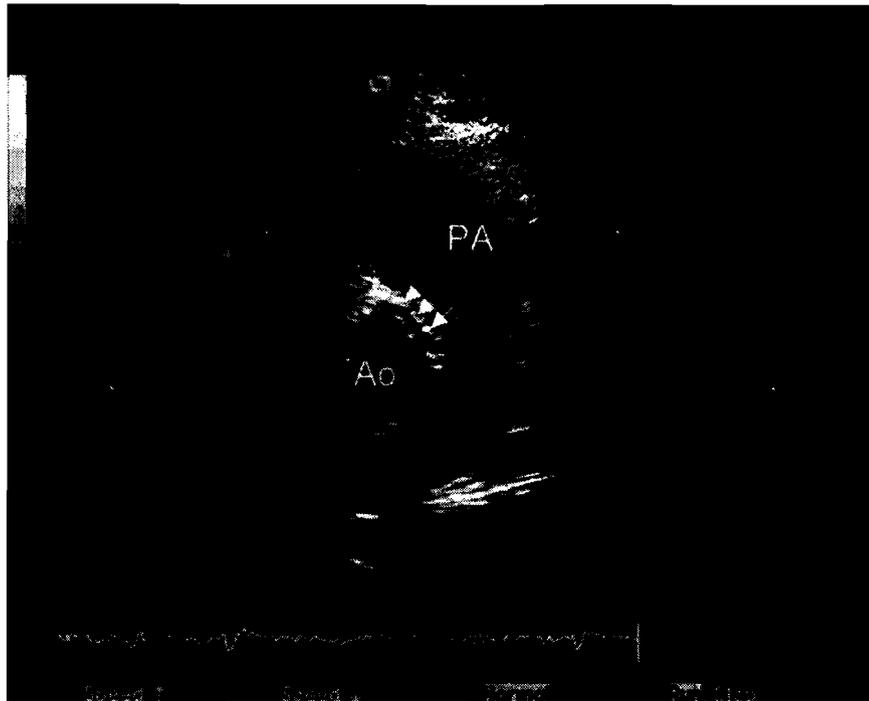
Two-dimensional echocardiographic image from a short axis view in a patient who has anomalous origin of the left coronary artery from the right sinus of Valsalva and an intramural course of the anomalous coronary. The anomalous left coronary artery can be seen arising from the anteriorly positioned right sinus of Valsalva and coursing intramurally within the anterior aortic wall (*arrows*) between the aorta (*Ao*) and the pulmonary artery (*PA*) towards the left sinus of Valsalva.
